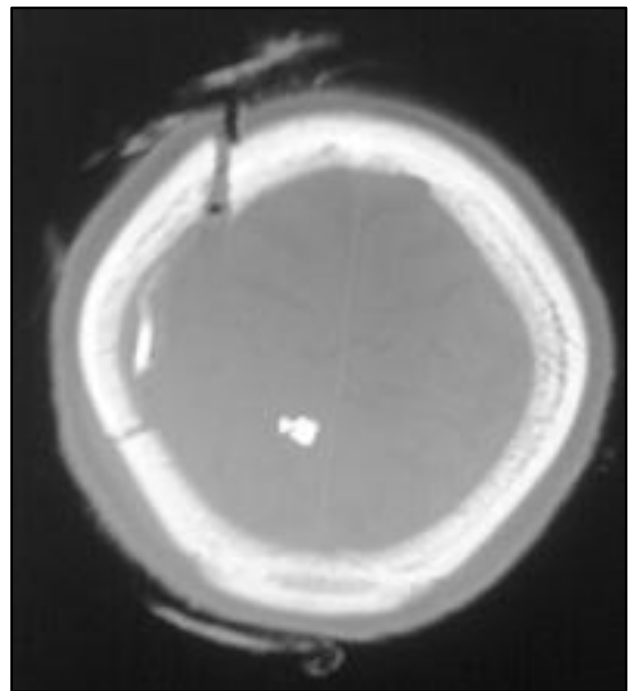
CT Axial Image showing Soft Tissue Swelling
